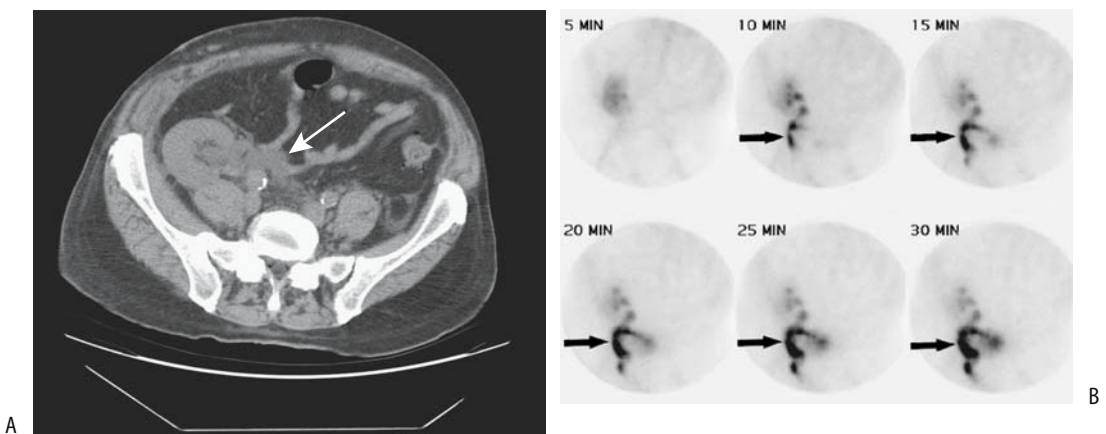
Urine leak after renal transplantation 1 week earlier. A: CT shows a fluid collection medial to the ureteropelvic junction (arrow). B: Dynamic renal scintigraphy using Tc-99m-DMSA identifies progressive tracer accumulation in this region (arrows). (Source: Titton R, Gervais DA, Hahn PF, Harisinghani MG, Arellano RS, Mueller PR. Urine leaks and urinomas: diagnosis and imaging-guided intervention. *RadioGraphics* 2003;23:1133–1147, with permission from the Radiological Society of North America.)
